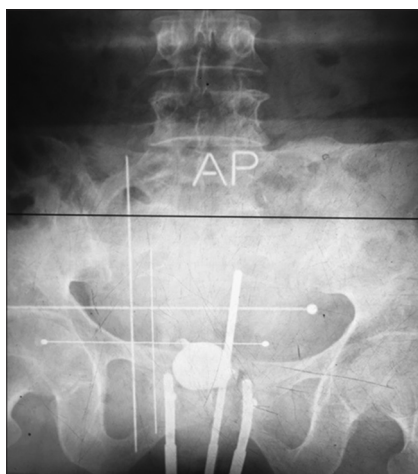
Radiograph anteroposterior view
